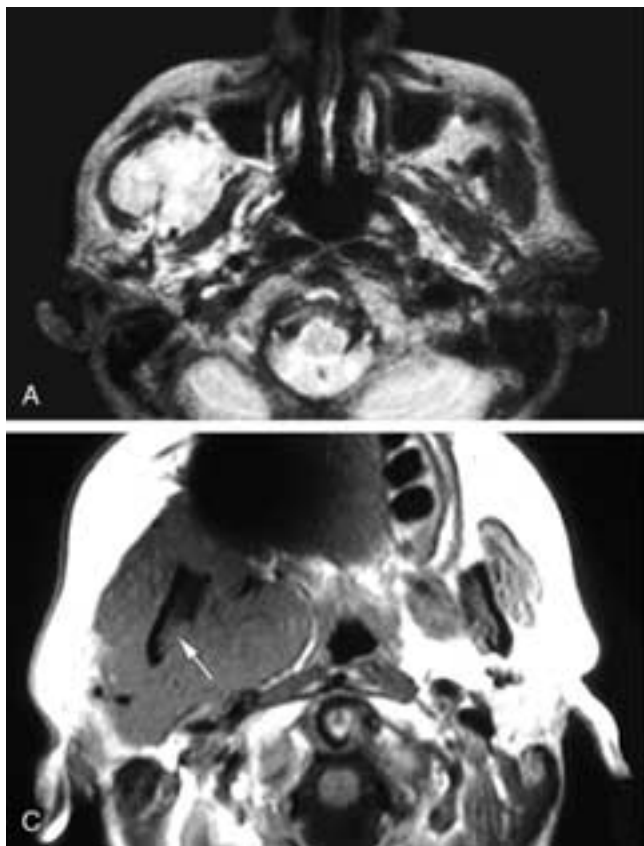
Axial T2-weighted MR image (A) shows a high signal intensity invasive mass in the right masticator space. The signal void of the normal bone of the mandibular ramus is destroyed, and the masticator muscles are displaced away from this fibrosarcoma. Axial contrast-enhanced CT scan (B) shows an infiltrating mass in the right masticator space, with invasion of the masticator space muscle, violation of the medial fascia, and extension into the parapharyngeal space. There is also some erosion of the right mandibular neck and anterior head in this patient with metastatic breast carcinoma. Axial T1-weighted MR scan (C) shows a large, homogeneous mass in the right masticator space that has invaded the ramus of the mandible (*arrow*). Despite the bone destruction, the masticator fascia confines the tumor, preventing it from spreading into the parapharyngeal space and the superficial soft tissues. Note the deformed but preserved parapharyngeal space fat of the prestyloid compartment on the right side in this patient with an undifferentiated sarcoma.
